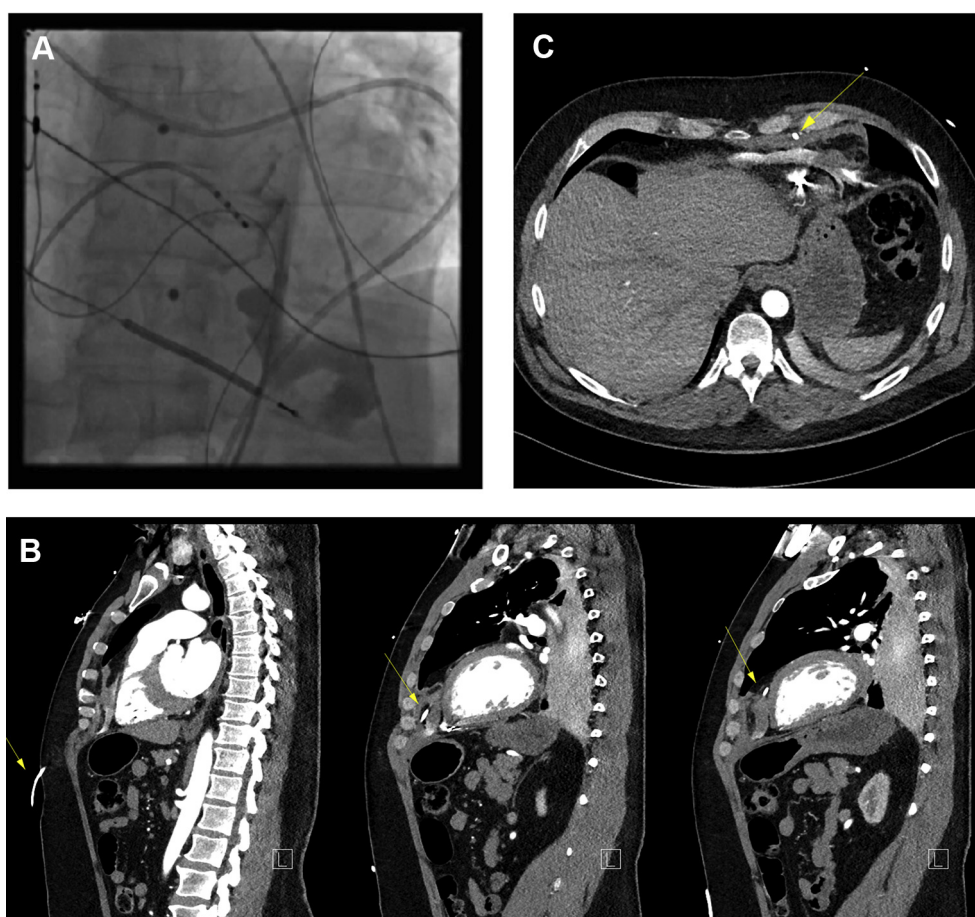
Damage to the left internal mammary artery (LIMA), patient 1. A: Fluoroscopy reveals contrast extravasation extrapericardially. B: Computed tomography (CT; sagittal view) demonstrates the anterior course of the pericardial drain. C: CT (axial view) shows that the pericardial drain is directly adjacent to the LIMA and courses through its side branch (arrow).
